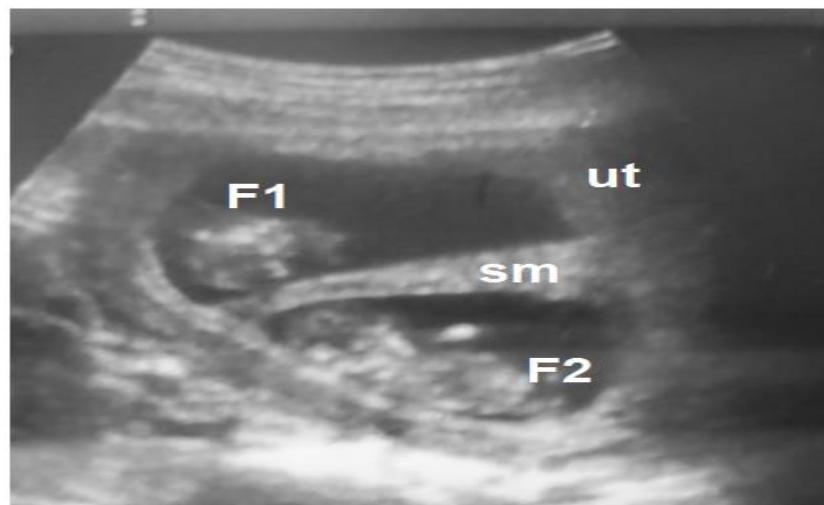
Sonogram showing twin pregnancy. Two foetuses (F1 and F2), sm is membrane separating both foetal sacs, ut is uterus.
